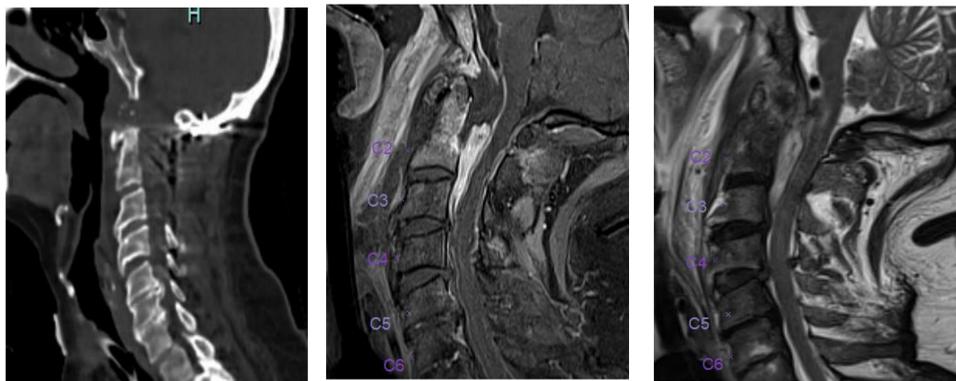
CT before Transoral Approach
